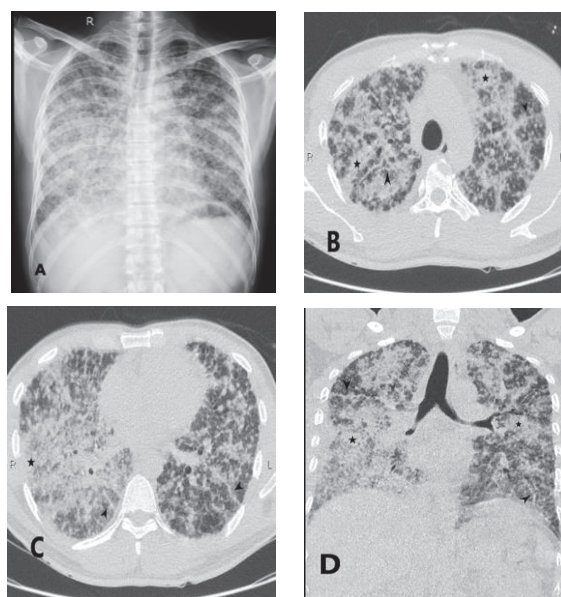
Initial chest X-ray (A) demonstrates bilateral diffuse reticular opacities with consolidation in the right lung predominant. Axial CT scan (B, C) and coronal reconstructed CT image (D) showed bilateral extensive septal thickening and reticular opacities (arrowhead) with consolidation (star).
